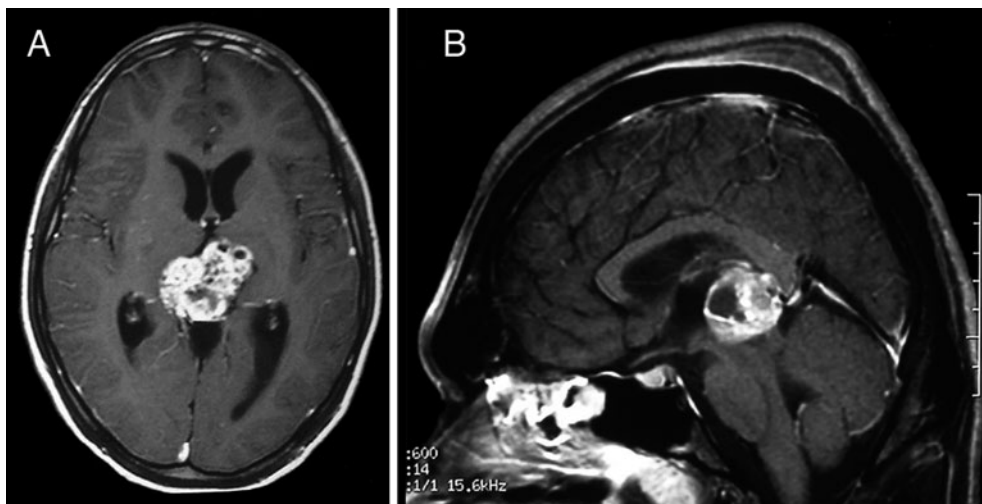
(a) Gadolinium enhanced axial MR image of 14-year-old boy with pineal immature teratoma. (b) Gadolinium enhanced sagittal MR image of 18-year-old boy with pineal germinoma
